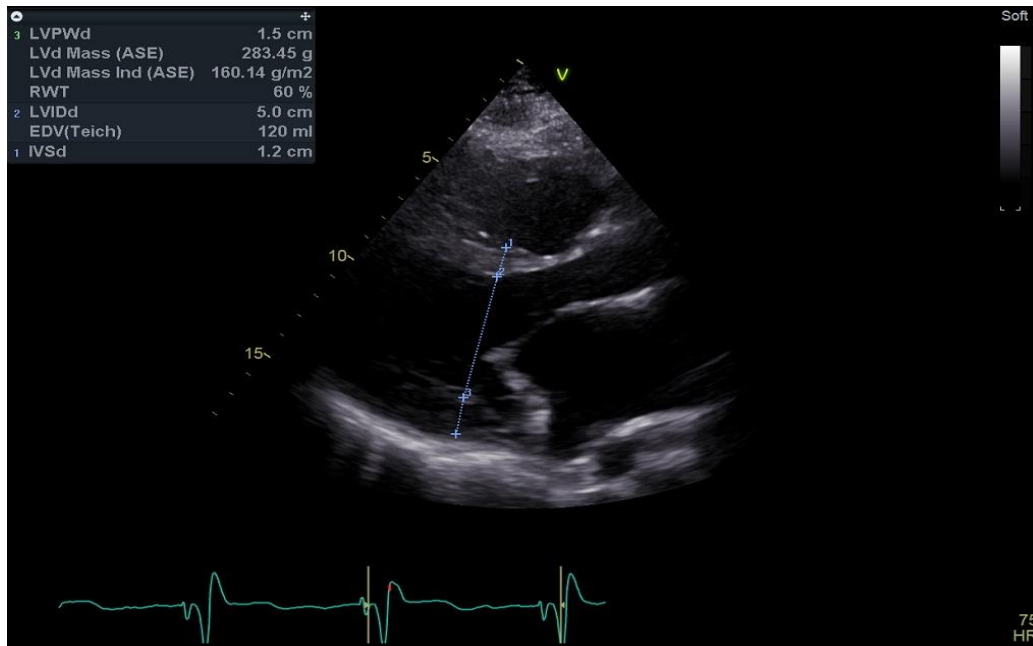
Parasternal long-axis view of left ventricle chamber quantification.
